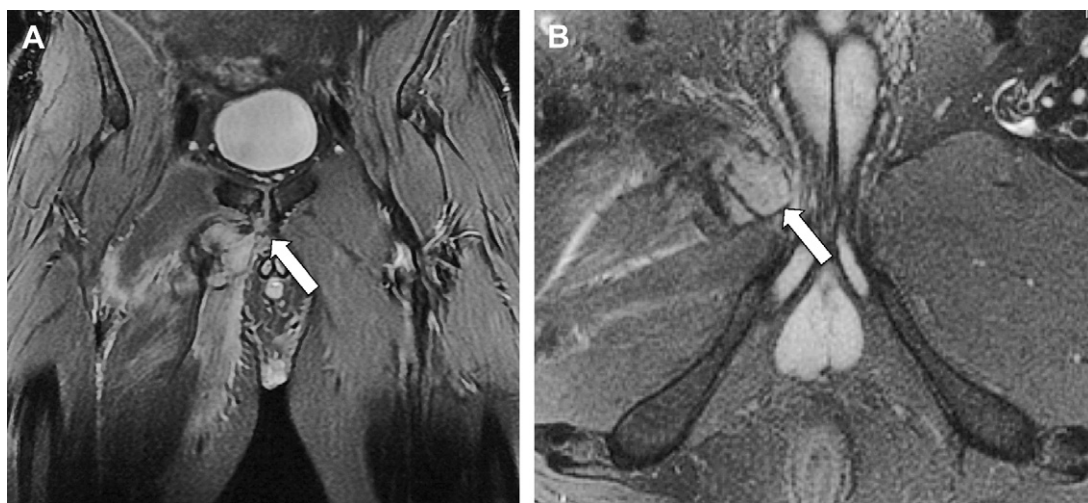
(A) Coronal fat-saturated T2-weighted MR image. Large acute proximal right adductor longus origin tear with hematoma formation, edema, and distal retraction of the tendon (arrow). This condition is potentially disruptive for the prepubic aponeurotic complex. (B) Axial fat-saturated T2 MR image demonstrating a hematoma and retracted adductor longus tendon (arrow).
